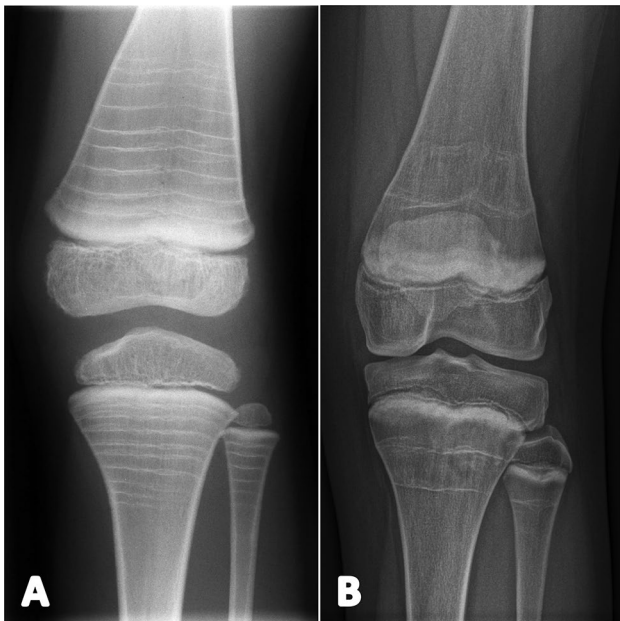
Effect of BPs and denosumab on bone metaphysis; left knee radiographs. A Band-like metaphyseal sclerosis in a boy diagnosed with OI by the age of 3.5 years, 3 years after the start of BPs (pamidronate intravenously at 4-month intervals). B Metaphyseal sclerosis in a 13-year-old girl long-term treated with denosumab because of a recurring spinal aneurysmal bone cyst
